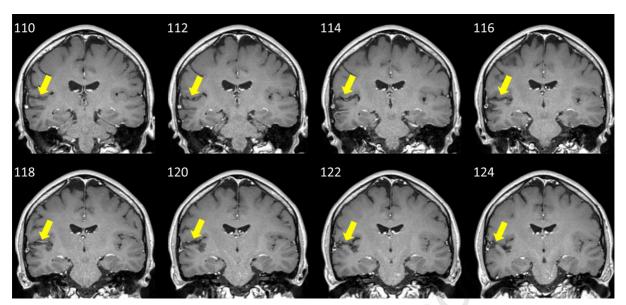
Coronal slices of the T1-weighted MRI image, separated by 2 mm, showing differences in the longitudinal relaxation time of tissues. These images were used to assess impingement of the lesion into medial Heschl's gyrus. These images demonstrate abnormal signal (darker parts of cortex) within auditory cortex: this is mainly in the planum temporale, lateral to medial Heschl's Gyrus (HG) in the right superior temporal plane. Yellow arrows point to the affected area. Images are displayed in radiological convention, with the right of the brain on the left side of the image. Y co-ordinates (mm) are displayed in the upper left of each slice.
